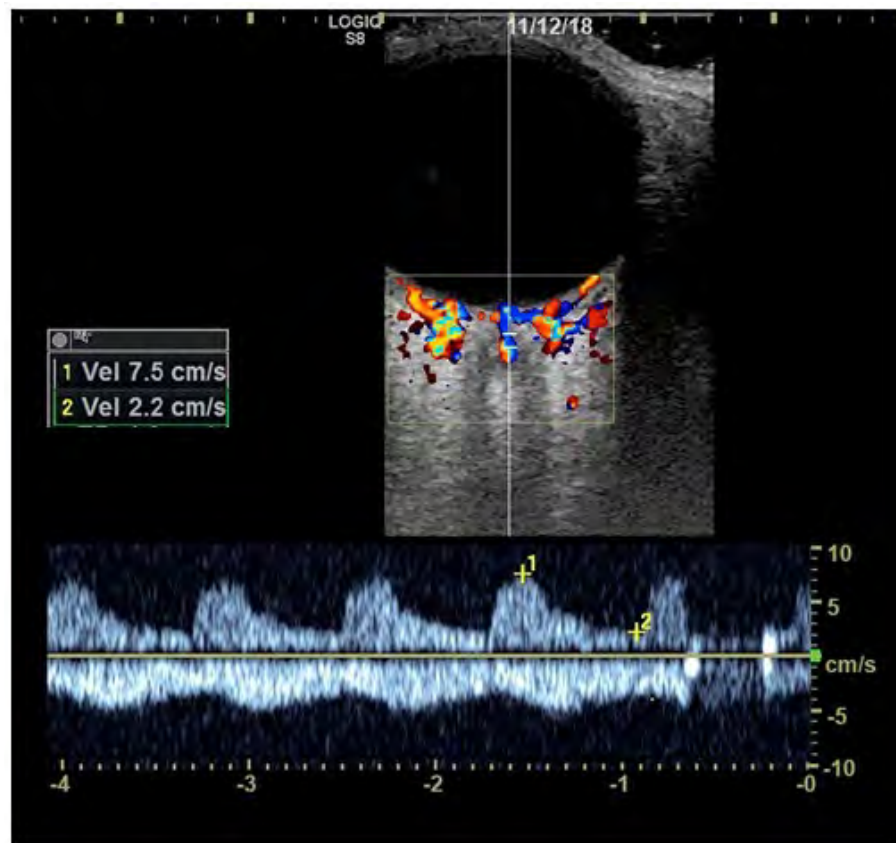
Transocular ultrasound of an affected eye in giant cell arteritis with reduced flow velocities.
